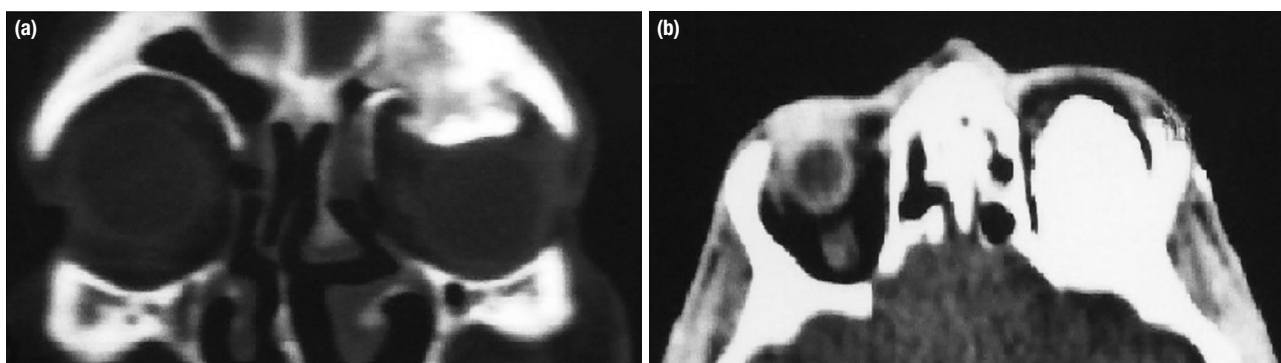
a, b. Coronal CT scan revealed a left frontal sinus osteoma extending into the orbit (a). Axial CT scan (b).
